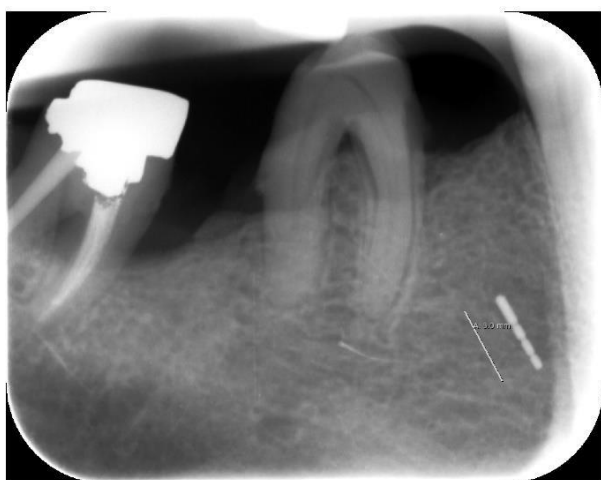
Cone-beam tomography showing the metallic opacity compatible with a broken tip of a periodontal probe. No close relationship to the mental nerve canal or supplying vessels was evident.
